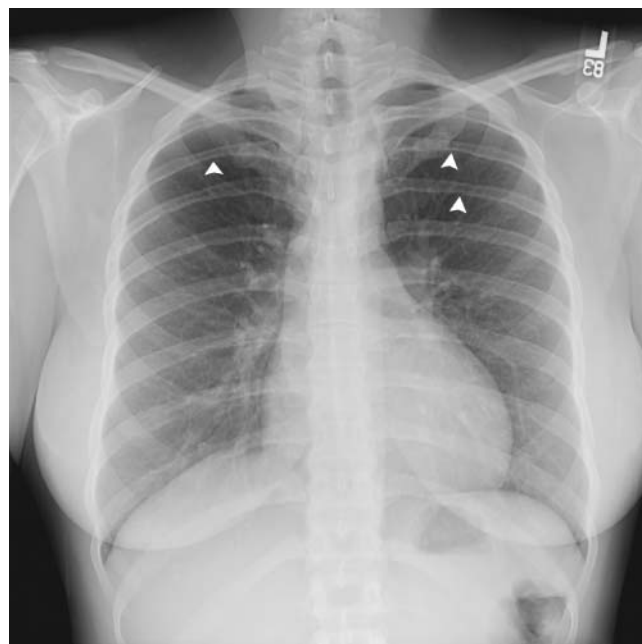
A 21-year-old female with a cough and fever underwent a chest radiograph to evaluate for pneumonia. Incidental note was made of bilateral rib notching (arrows). This was confirmed at time-resolved magnetic resonance angiography to be an aortic coarctation with multiple arterial collaterals resulting in the bilateral rib notching.
